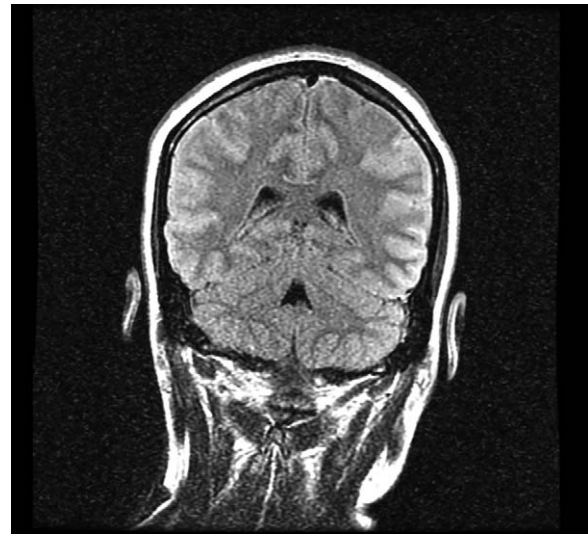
MRI—nonpathological findings. MRI=magnetic resonance imaging.
